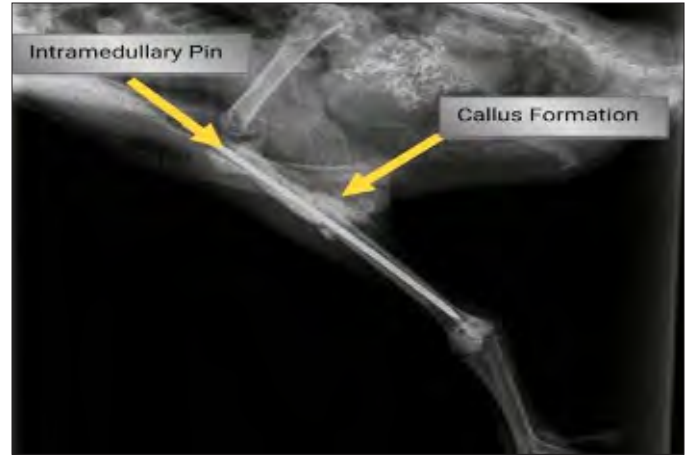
Lateral radiograph of operated limb revealed minimum callus formation at fracture site on 21<sup>st</sup> postoperative day
